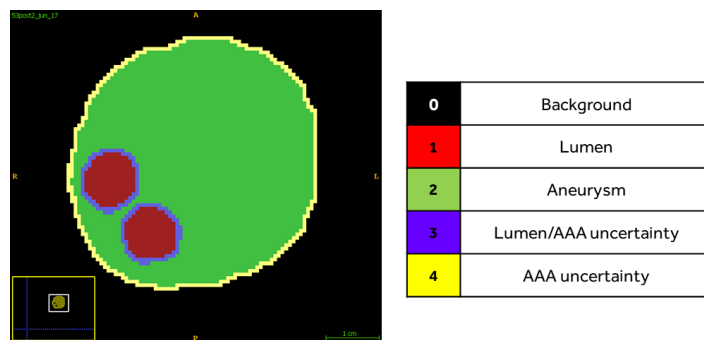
Example of 53post2 CTA post-operative 5-class uncertainty mask.
